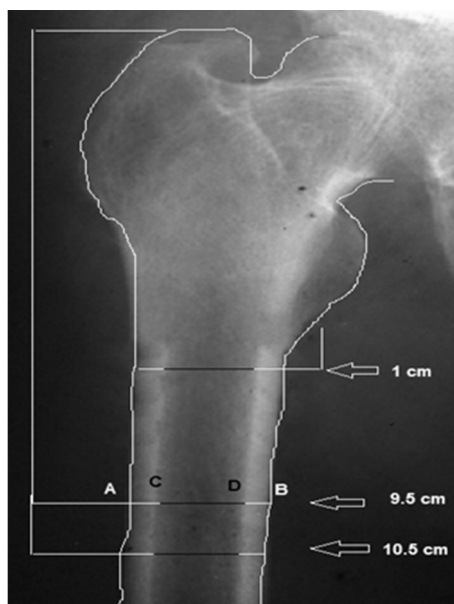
A plain pelvic Xray shows measurements were obtained at 9.5 cm and 10.5 cm from the tip of the greater trochanter and 1 cm of lesser trochanter. Cortical thickness was calculated by subtracting the medullary diameter from the femoral shaft diameter (AB - CD). The cortical thickness ratio was defined as the percentage of the cortical thickness to its femoral shaft diameter [(AB - CD)/AB].
